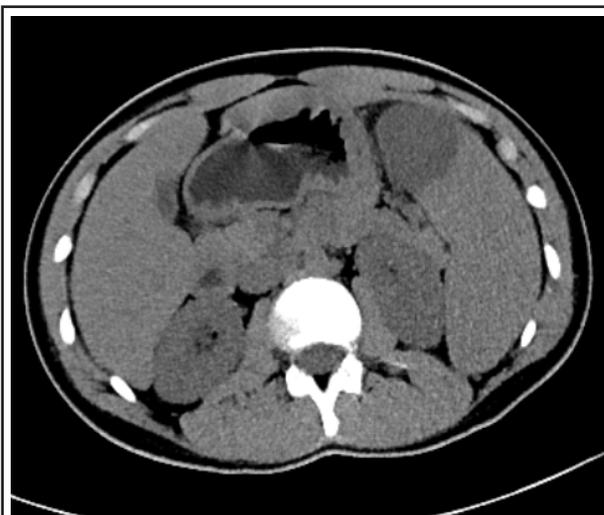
CT scan showing mild hepatosplenomegaly with a 4.3 cm sub-capsular low-attenuation area without capsule destruction consistent with infarction.
